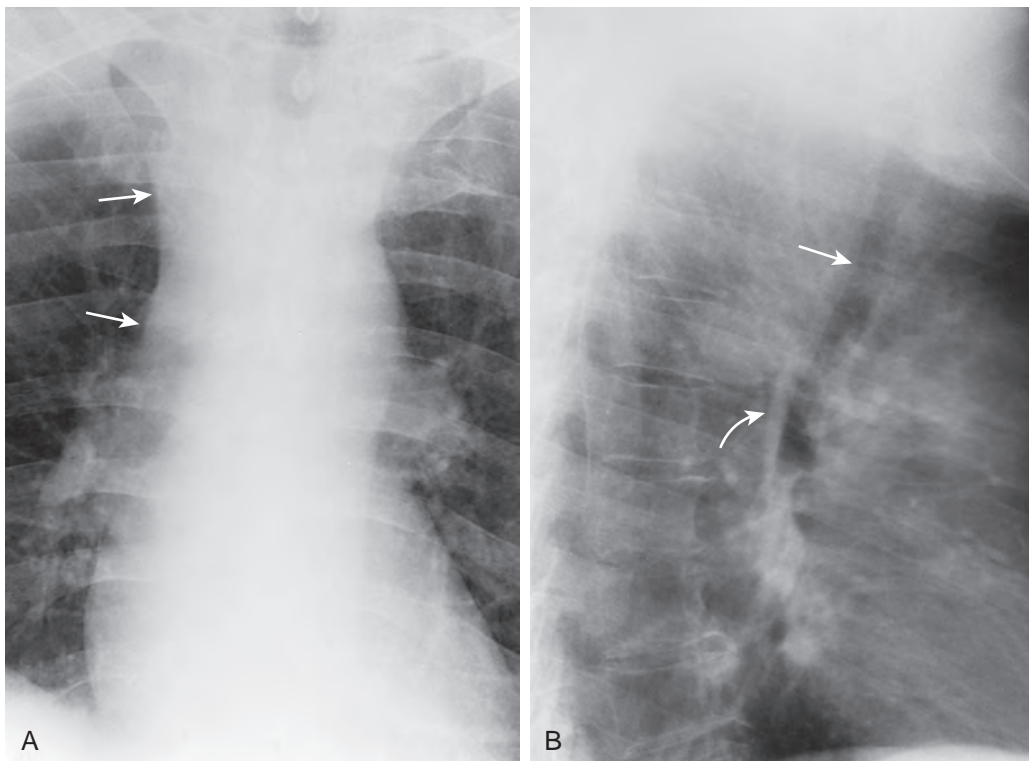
Advanced esophageal carcinoma with abnormal chest radiographs. A. Posteroanterior chest radiograph shows widening of the superior mediastinum on the right (arrows). B. Lateral radiograph shows increased soft-tissue density in the retrotracheal space with slight anterior bowing of the trachea (straight arrow) by an advanced esophageal cancer in this region. Also note thickening of the retrotracheal stripe inferiorly (curved arrow) caused by direct invasion of this area by tumor. (Courtesy Wallace T. Miller, MD, Philadelphia.)
